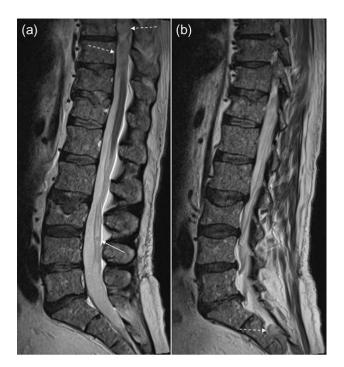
Leptomeningeal infiltration (spinal). Small nodular lesion in cauda equina at level L3/L4 (arrow) and more confluent lesions behind Th9–Th10 and S2–S3 (stippled arrows) on sagittal T2-weighted images near the midline (a) and laterally (b) in the patient with leptomeningeal PCL.
